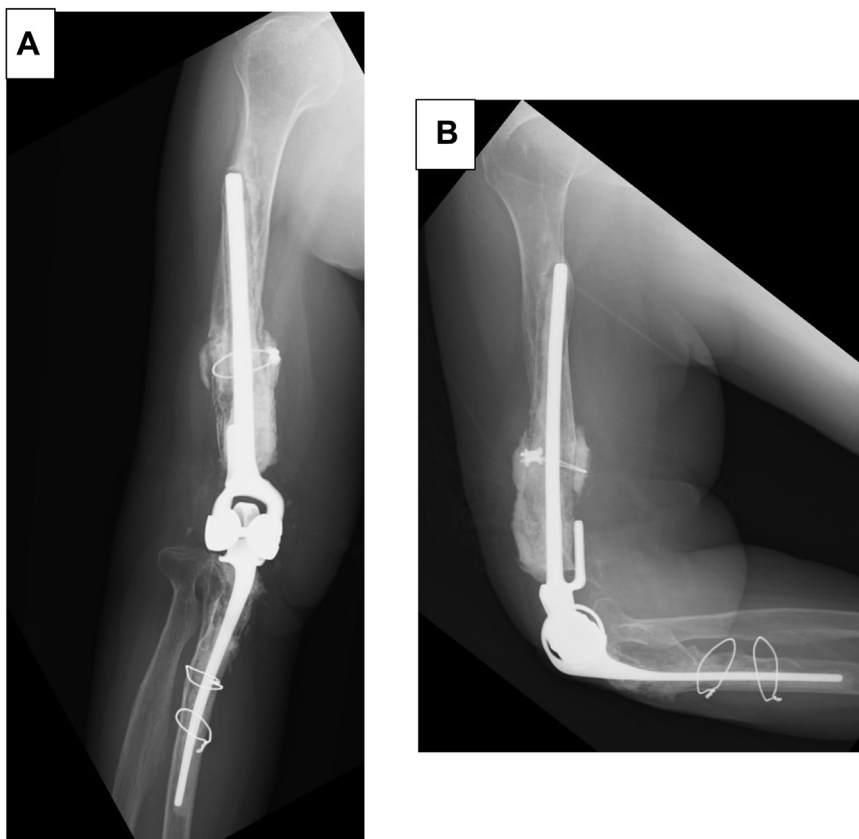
Preoperative X-ray. Five years after the previous operation, anteroposterior (A) and lateral (B) views show re-loosening of the humeral stem along with varus deformity of the distal cemented part, and perforation of cortical bone at the tip of the stem. No loosening of the ulnar side is observed.
